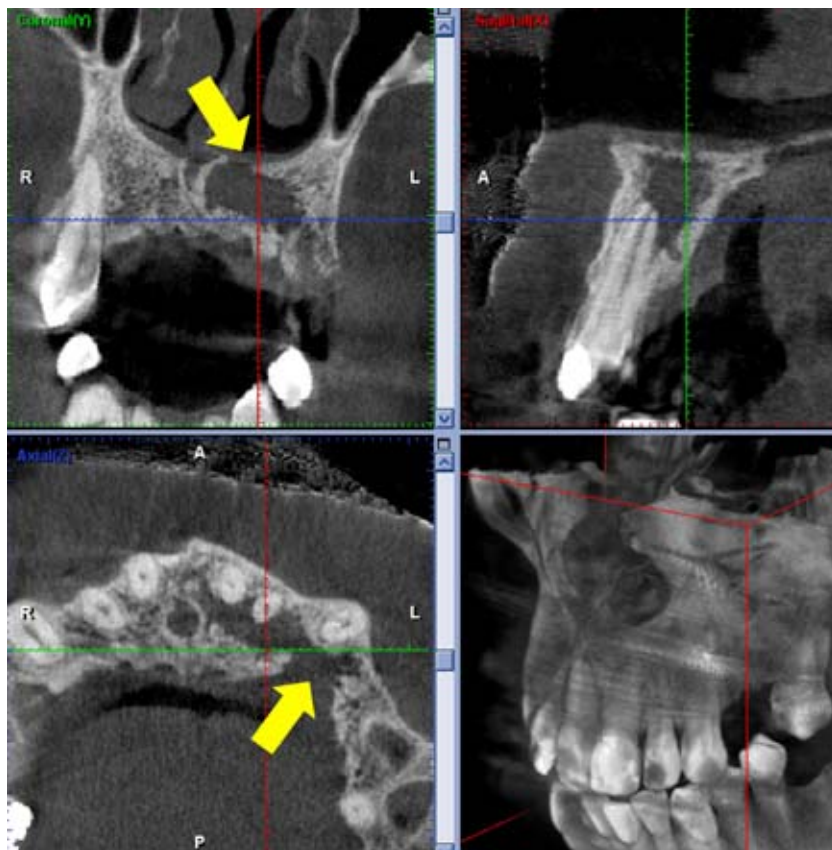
Coronal, axial and sagittal slice (CBCT) regio 23. Extensive osteolytic process starting from tooth 23 with loss of the bony barrier to the nasal floor as well as the palatal corticalis (palatum durum).
